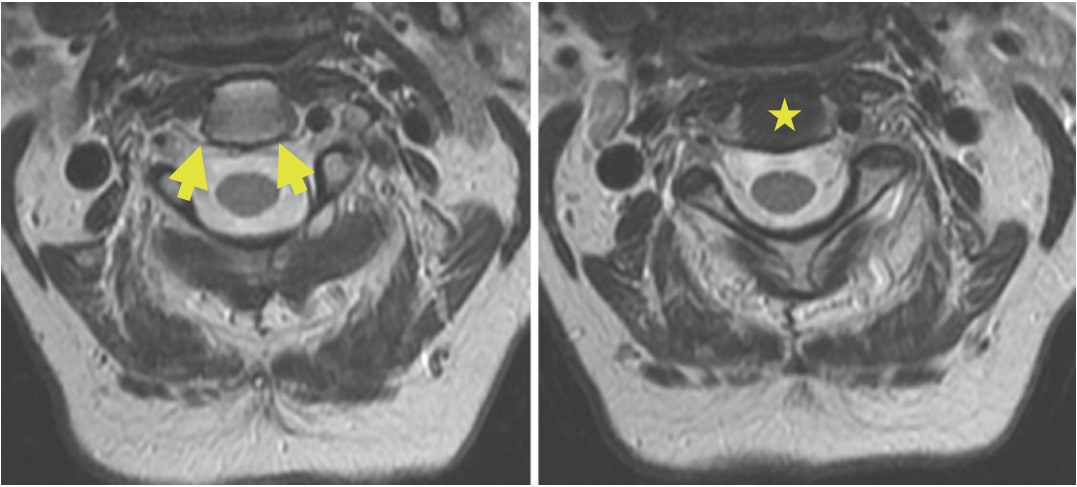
Axial T2-weighted imaging of the cervical spine demonstrates a normal disk (yellow star) which does not extend beyond the margins of the vertebral body (arrows)
